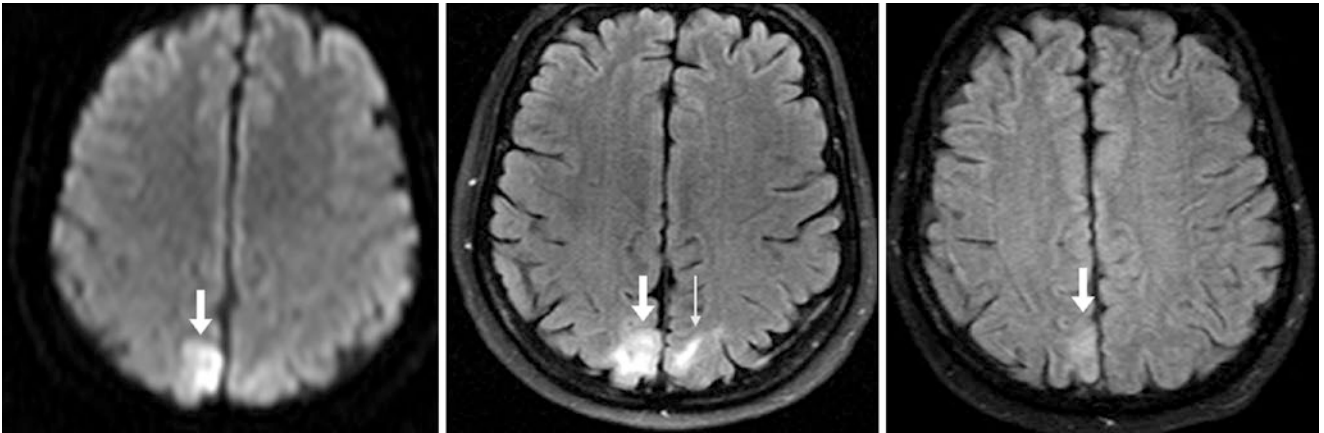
Comparison case of infarct in PRES. A 57-year-old had a 1.5 T DWI MRI (*left*) that demonstrated focal reduced diffusion (*arrows*) within a larger region of “mild” cortical edema on FLAIR (*middle*). Contralateral edema (*thin arrows*) is also seen. On a repeat FLAIR image 1 month later, the edema had improved bilaterally (*right*)
